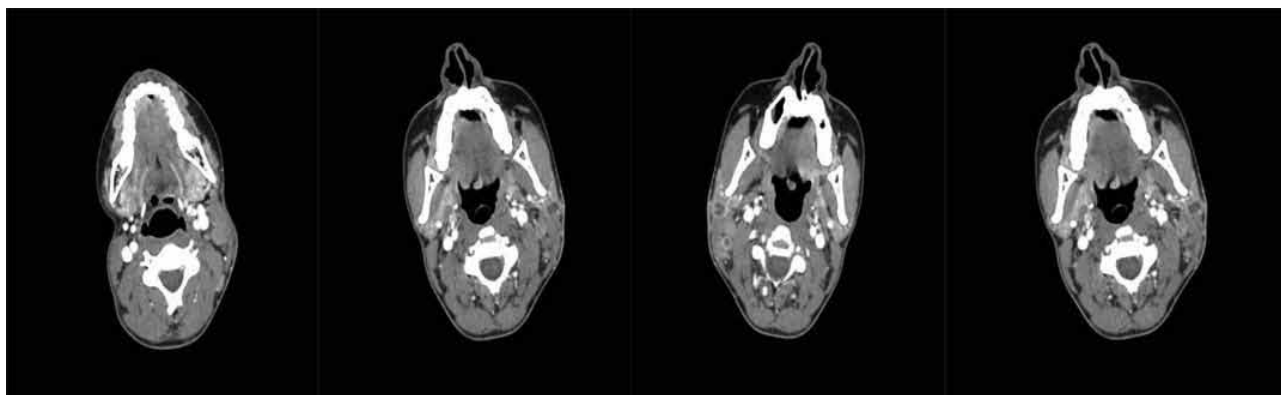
CT scan of the neck showed multiple abnormalities of the left cervix such as scared enlarged cervical nodes, some with central necrosis and peripheral enhancement.
